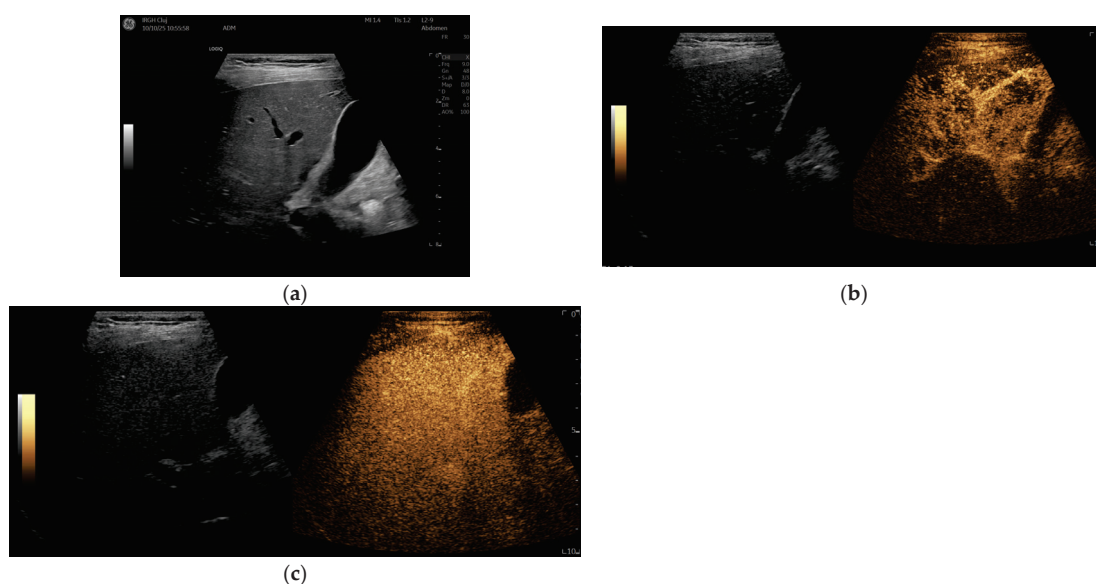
Ultrasound (US) evaluation after 9 years of Etanercept treatment. (a) B Mode US shows no evident liver nodules; (b) Contrast-enhanced ultrasound (CEUS) arterial phase shows an inhomogeneous pseudonodular enhancement of the right lobe; (c) CEUS in parenchymal phase—no hypoenhanced nodules are seen.
